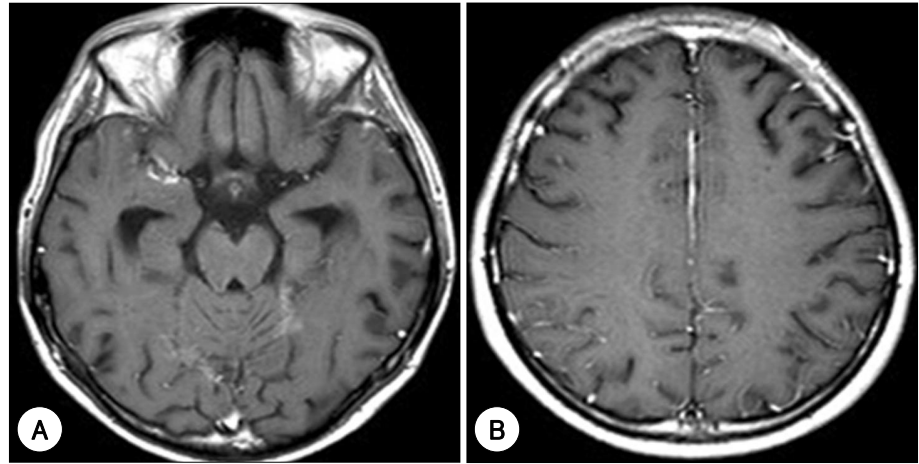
One month later, T1-weighted gadolinium-enhanced axial MRI scans showing increased enhancement at right mesial temporal lobe (A) and a newly developed leptomeningeal enhancing lesion at the right parietal lobe (B).
